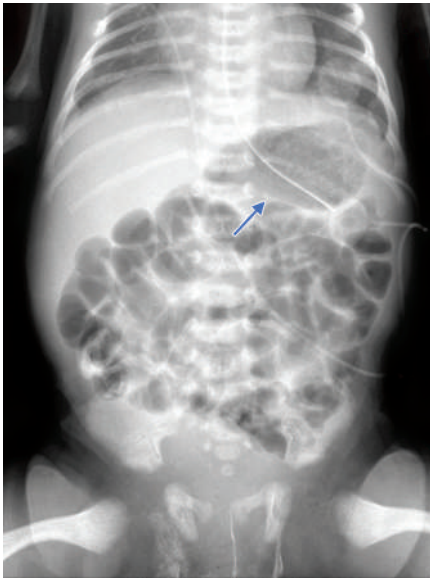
Scout supine frontal abdomen radiograph showing a distended stomach (arrow) with a nonspecific nonobstructive bowel gas pattern
